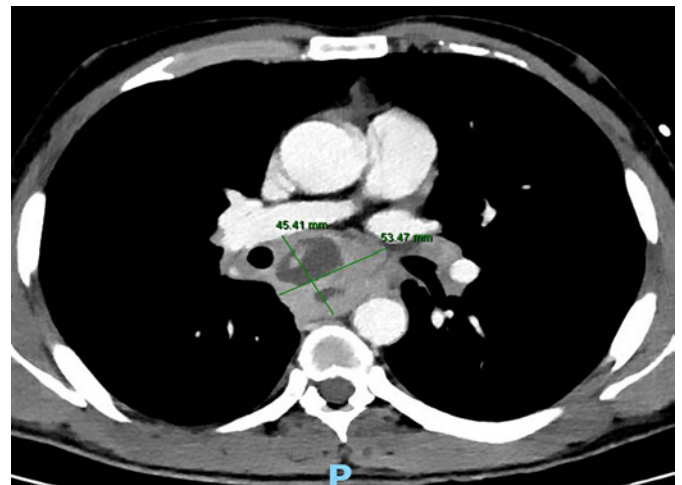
Axial contrast-enhanced CT (mediastinal window): large subcarinal mass (54 \times 45 mm) with heterogeneous liquefactive areas in continuity with a thickened esophageal wall.
